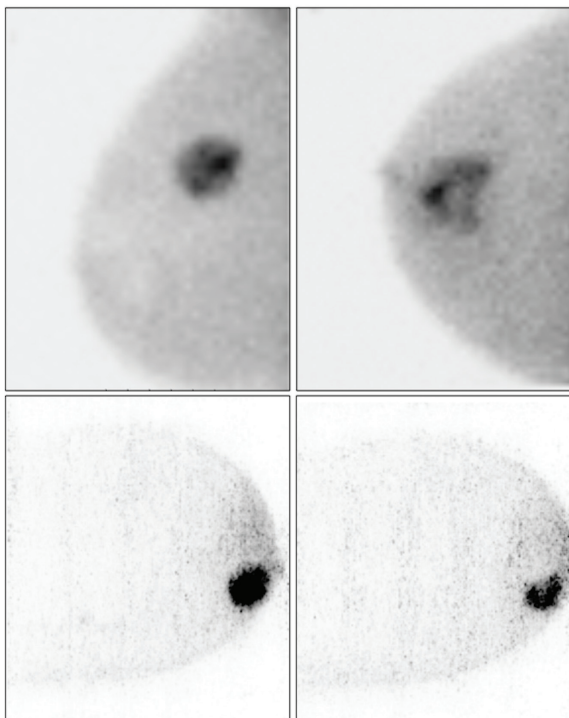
Above, heterogeneous uptake of ^{99m}Tc -MIBI in invasive ductal breast carcinoma with a 3 cm lesion (on the left) and a 5 cm lesion (on the right) as shown using breast-specific gamma-imaging. Below, in another patient uptake heterogeneity of ^{18}F -FDG is seen after the first cycle of neoadjuvant chemotherapy in the superior part of the lesion (on the right), which was homogenous at baseline acquisition (on the left) with a dedicated hanging breast PET scanner.
